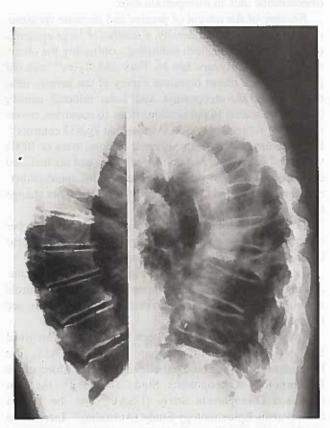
Typical roentgenograms of a case of osteoarthritis (L) and of osteoporosis (R).
